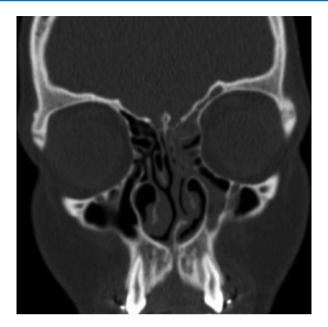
Non-contrast coronal CT of an 11-year-old female undergoing FESS for symptomatic chronic unilateral rhinosinusitis. Note septal deviation and ipsilateral hypoplastic maxillary sinus
